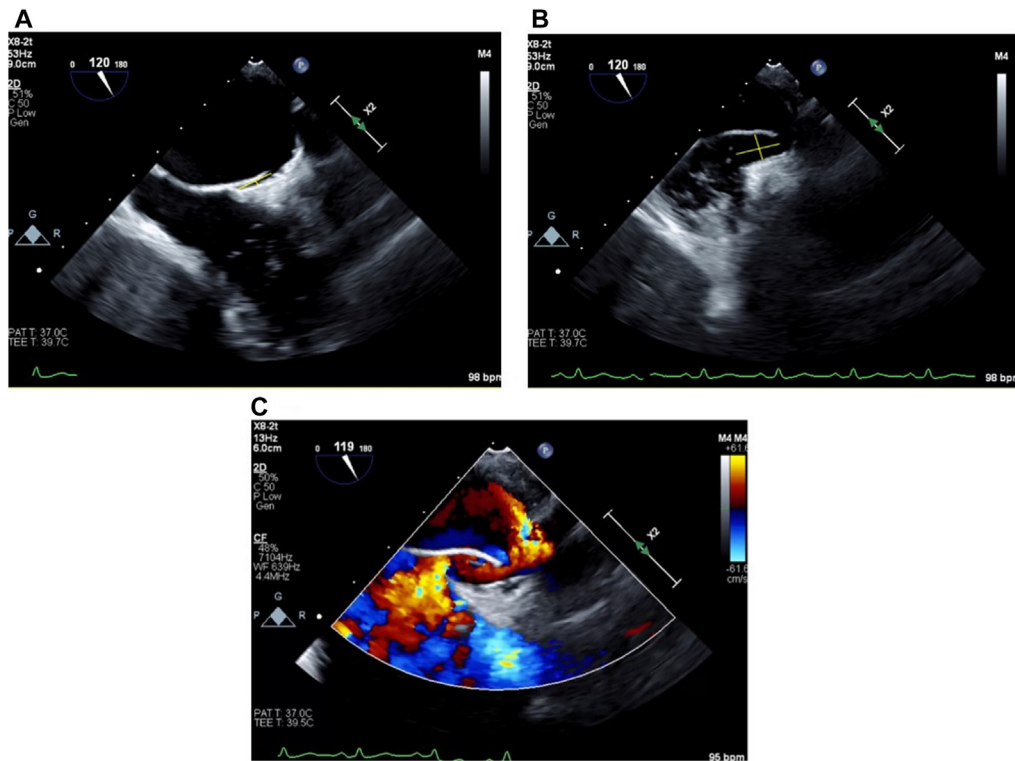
Two-dimensional TEE, midesophageal level long-axis (120°) view, demonstrates (A) the PFO at baseline (tunnel length, 1.13 cm; height, 0.19 cm) and (B) the PFO with deep inspiration (tunnel length, 1.35 cm; height, 0.8 cm) and with color-flow Doppler (119°), which demonstrates the right-to-left shunt (C).
